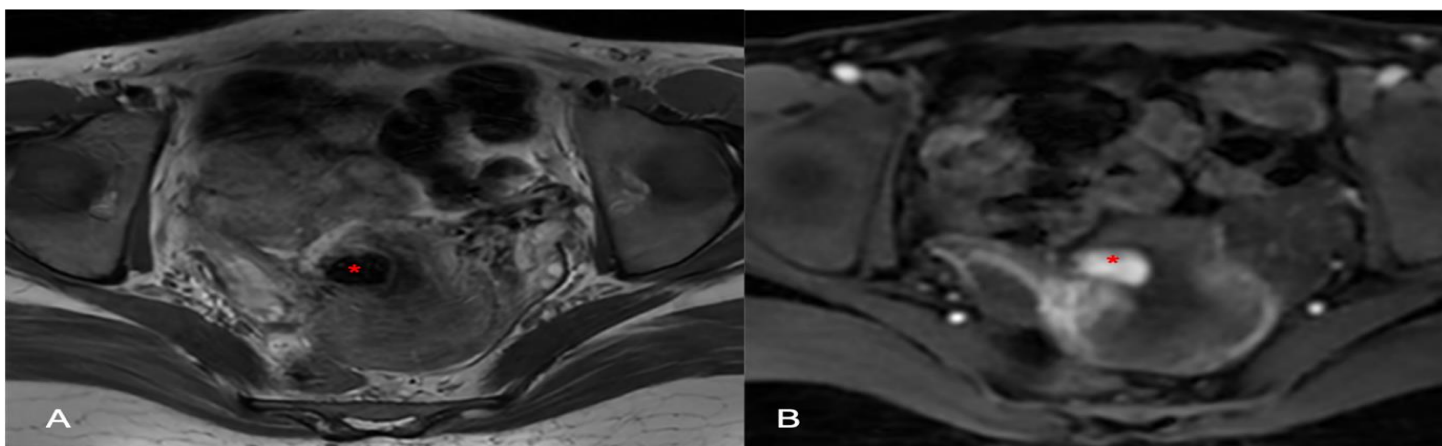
(A-B): T2 weighted axial Magnetic Resonance Image showing a large flow void lesion (Red asterisk) in the uterine myometrium on right side projecting into the endometrial cavity (A). T1w post Gadolinium axial image showing intense enhancement of the lesion in the early arterial phase without any enhancement of early draining veins (B).
